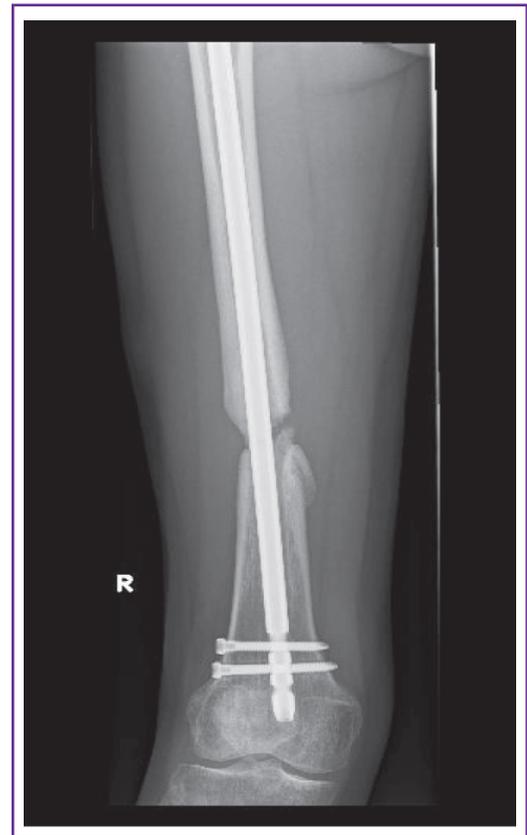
X-ray of a fracture non-union
